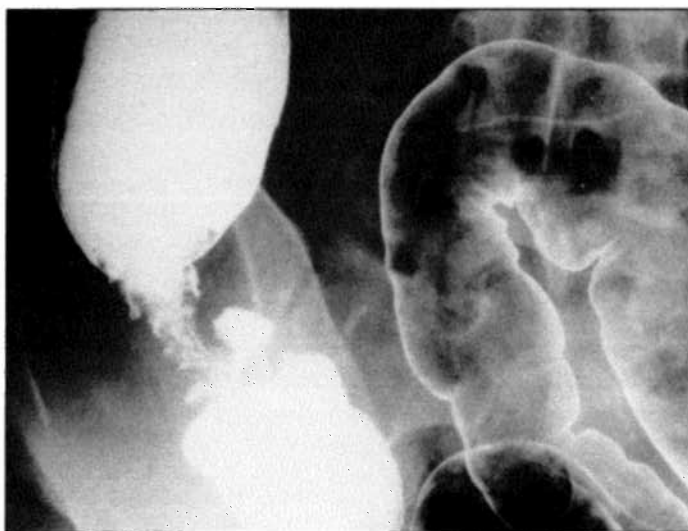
(Below) A spot radiograph of the cecum shows a somewhat focal area of narrowing present adjacent and superior to the ileocecal valve. The edges taper smoothly toward this narrowed region; the mucosa does not appear ulcerated.
